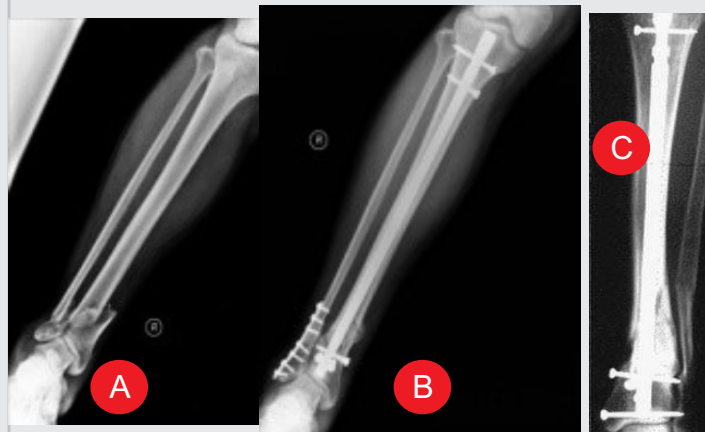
A- Radiographs showing anteroposterior views of freshly displaced distal one third shaft tibia fracture. B Fracture treated by nailing with Poller screw which is used as tool for obtaining reduction and alignment. C alignment and callus formation at 4 months.
